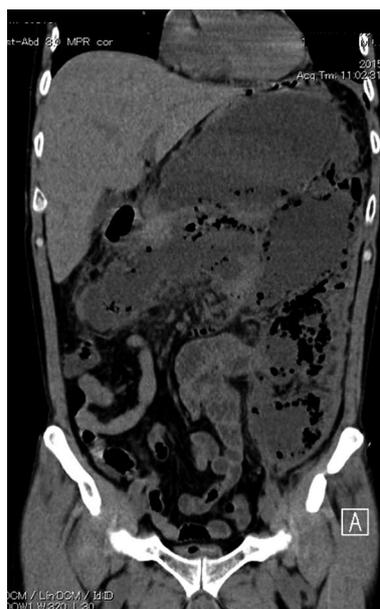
Abdominal computed tomography scan showing a huge multilocular walled-off necrosis replacing the body and tail of the pancreas, which extended to the pelvis. Gas bubbles were observed in the cavity.
